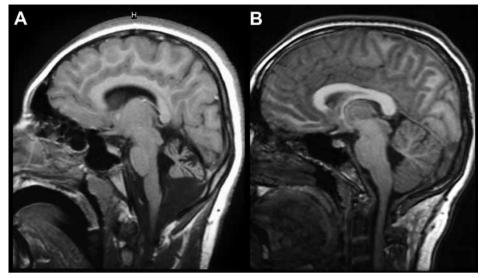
Brain sagittal T1 magnetic resonance imaging of one of the brothers (A), age 16, showing micro-cephaly and profound cerebellar atrophy compared to age-matched control (B).
